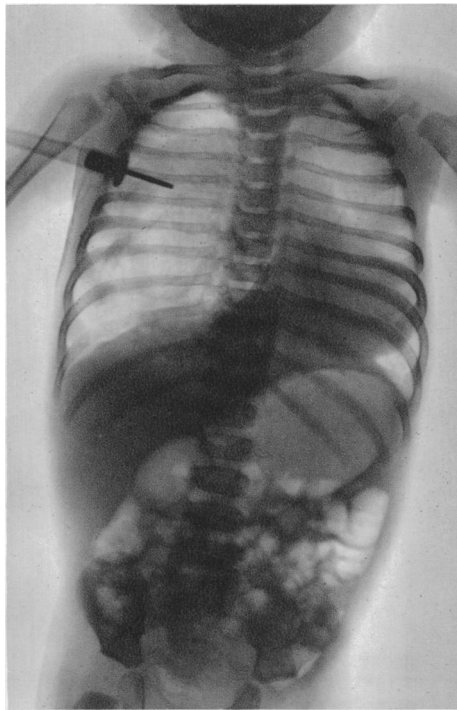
Radiograph showing the partially expanded lung and a pneumothorax. September 12, 1936.
